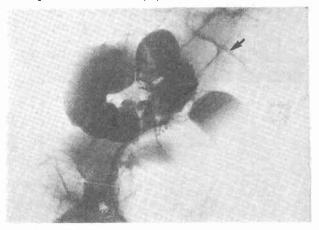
X-ray; covered perforation (\mathbf{P}) .
